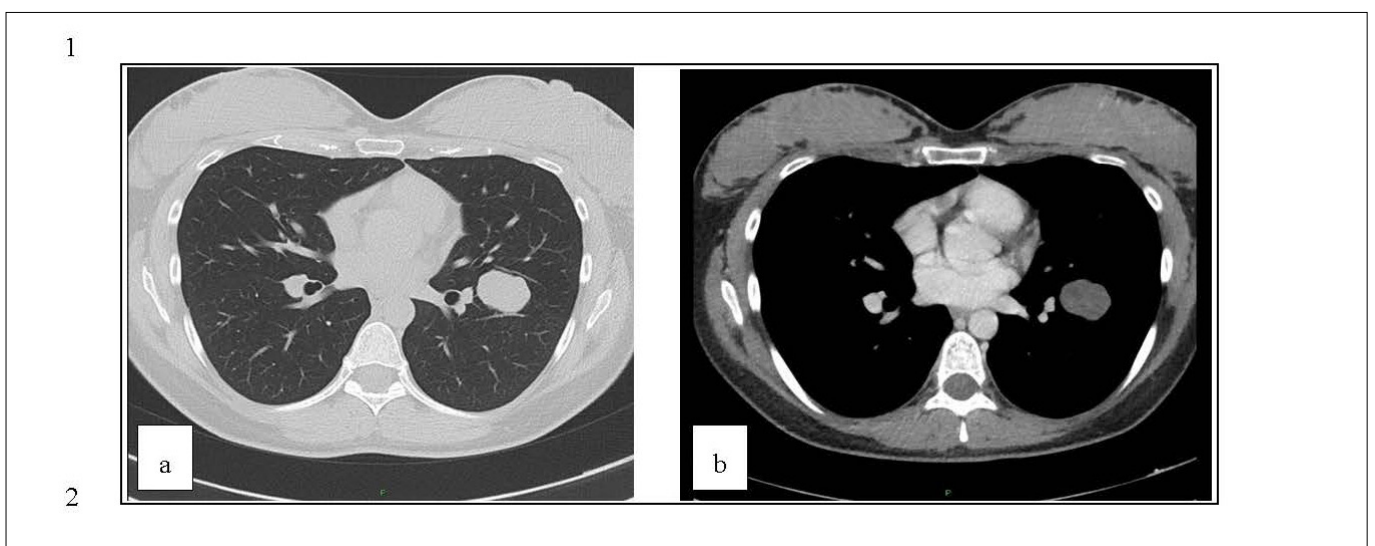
CT scan revealing the stability of the left lung lesion in size, morphological presentation and density 6 months after the delivery.
